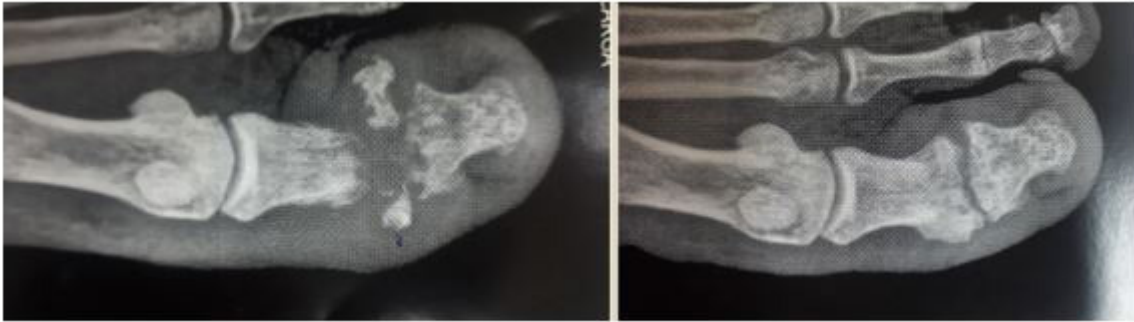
Radiography of a patient of this study, before (left) and after (right) a-PDT
